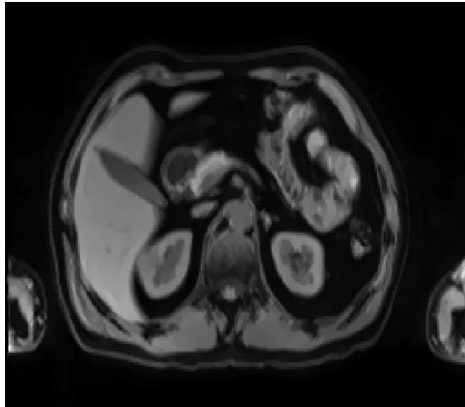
Input Kidney Image in MRI
